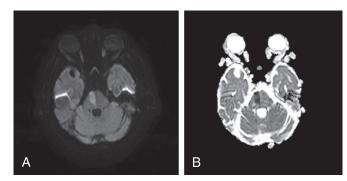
Acute pontine infarct (A) axial DWI and (B) axial ADC. The patient presented with acute left-sided weakness and slurred speech. An acute right paramedian pontine infarct demonstrates restricted diffusion on DWI and ADC images. Note asymmetry of the lesion compared with central pontine myelinolysis.
